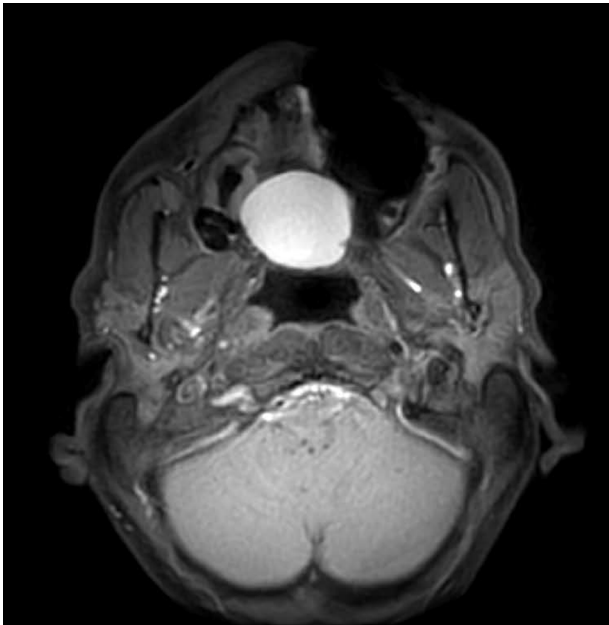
T1 MRI axial view, the lesion appears as a spontaneous hypersignal suggestive of protein content.
